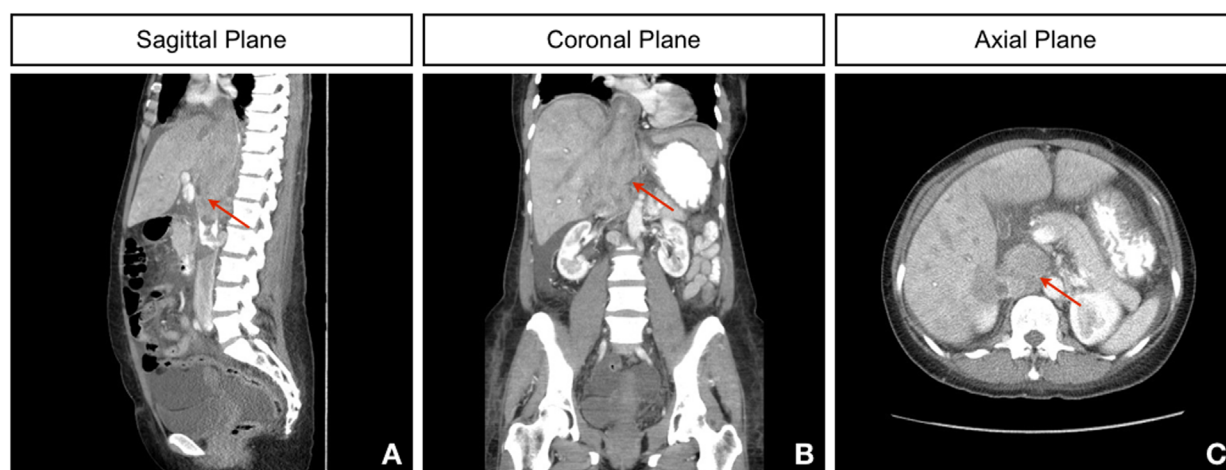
Abdominal computed tomography scan of the patient at presentation, presented in the sagittal (A), coronal (B), and axial (C) planes. The red arrows denote the tumor, which is seen as a heterogenous mass arising from the inferior vena cava and extending into the right lobe of the liver, the right adrenal gland, and the right atrium.
